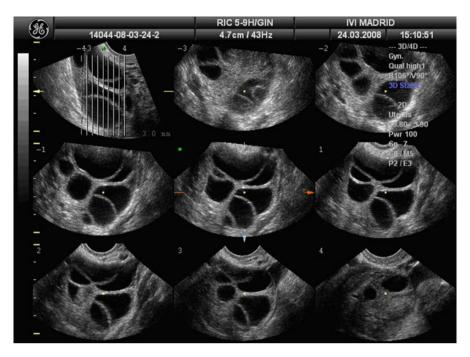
Hyperstimulated ovary. TUI mode allows obtaining millimetric images of the selected structure. Reproduced with permission, from Puente and Garcia-Velasco. In: Rizk B (ed). Ultrasonography in Reproductive Medicine and Infertility. Cambridge University Press 2010, chapter 8, 68
